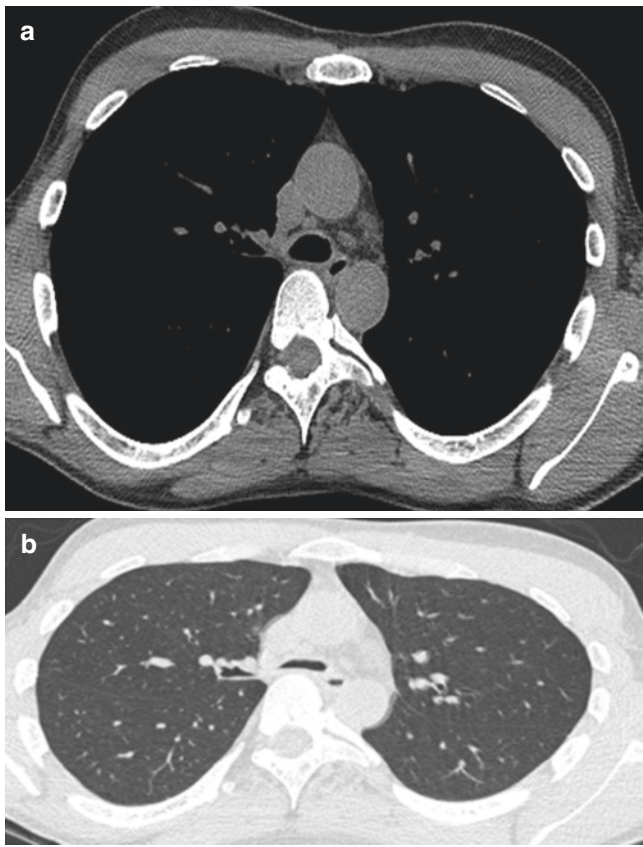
A CT scan of the chest of a 32-year-old man with relapsing polychondritis. (a) Inspiratory view demonstrating a thickened tracheal wall with mild narrowing. (b) On expiration, there is collapse of the tracheal lumen
